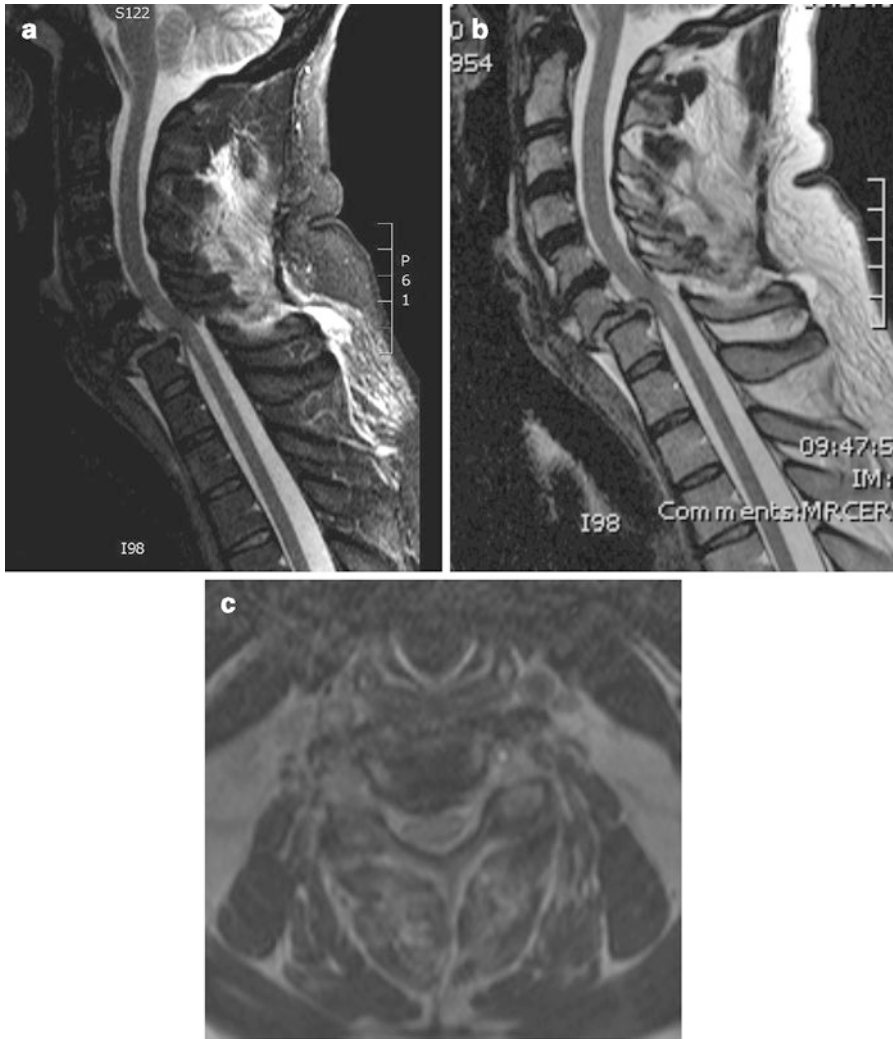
(a) T1 sagittal MRI of the spine. (b) T2 sagittal MRI of the spine. (c) T1 axial MRI of the spine
